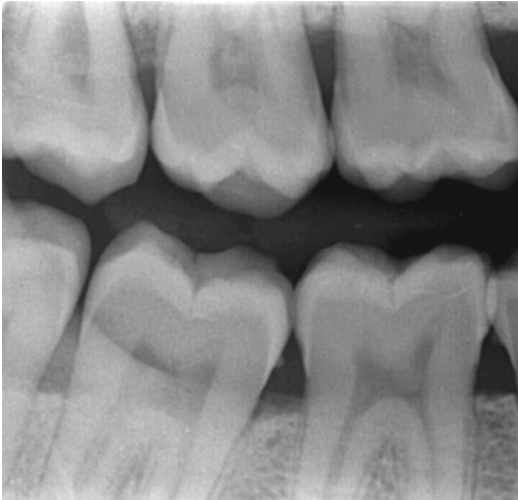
Bitewing radiograph
